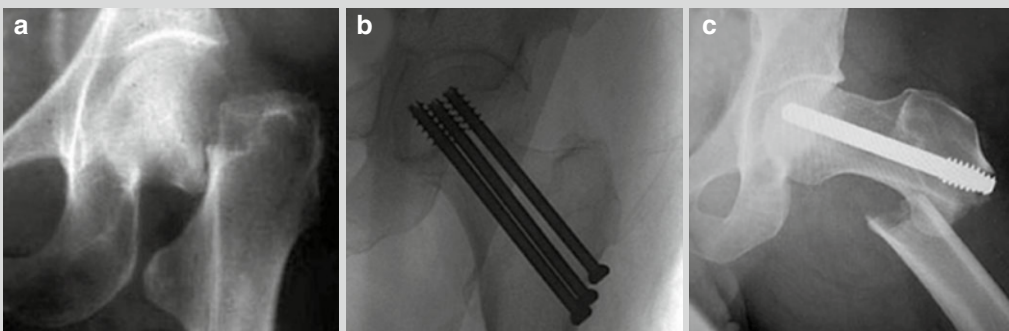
(a) Radiograph of preoperative fractured hip, (b) radiograph of postoperative *left* hip repaired by internal fixation screws, and (c) radiograph of an
